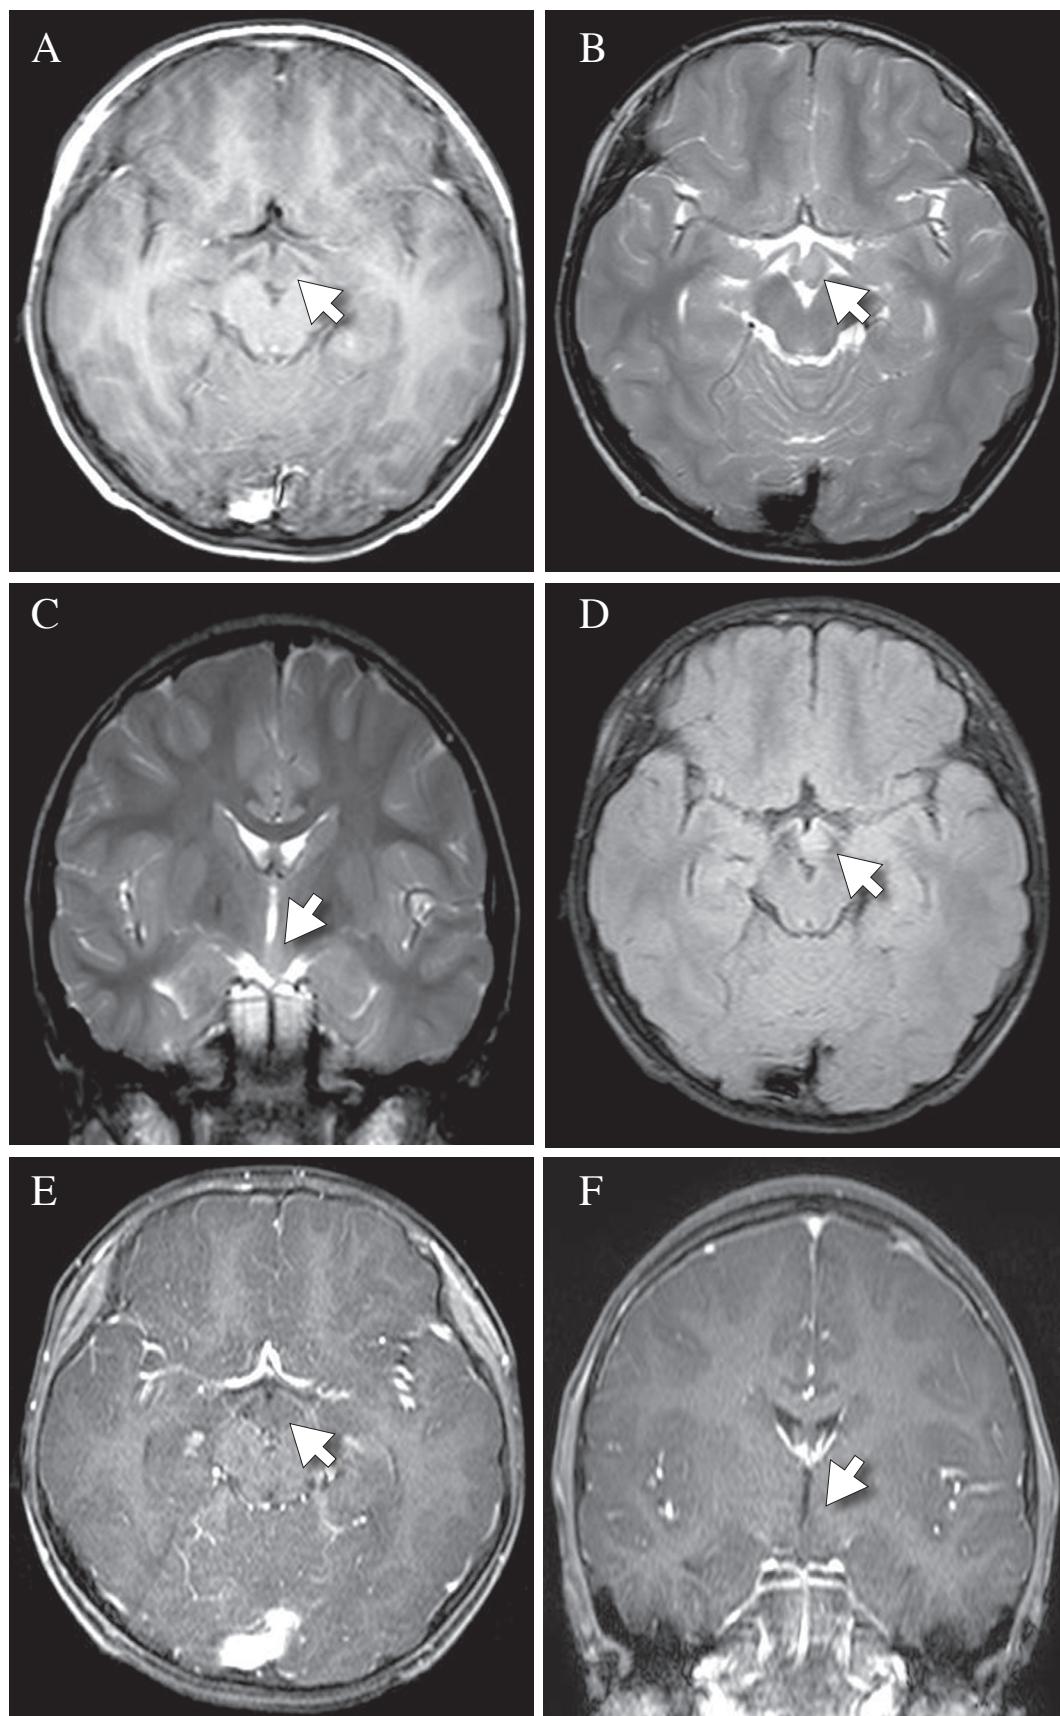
MRI scan of the brain demonstrated small ill defined lesion at left side of hypothalamus (tuber cinereum) about $1.23 \times 1.21 \times 0.87$ cm (white arrow), which had slightly decreased signal intensity in T1W (A, axial view), and slightly increased signal intensity in T2W (B, axial; C, coronal view) and FLAIR (D) without definite enhancement (E, axial; F, coronal view).
